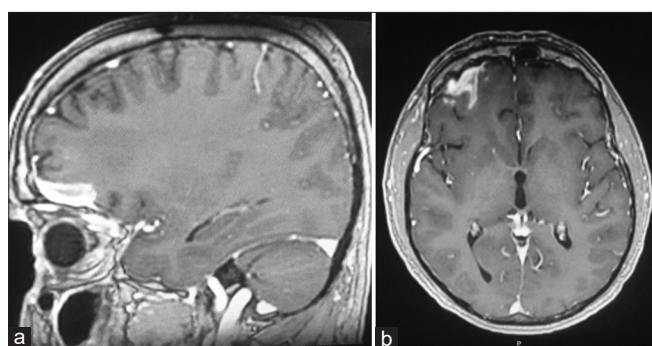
(a) Sagittal T1-weighted MR images , (b) axial T1-weighted MR images post gadolinium showed dural based hyperintense enhanced lesion.
